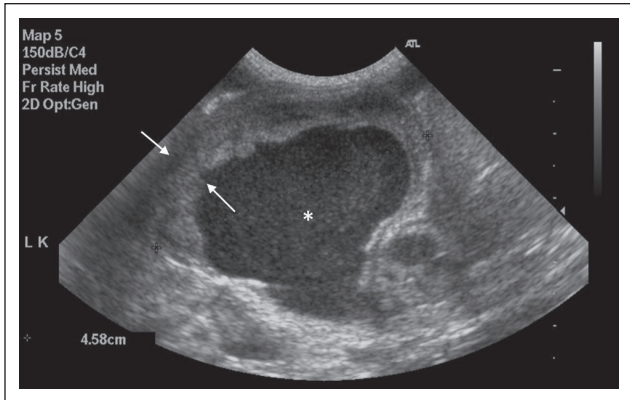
Hydronephrosis in the left kidney at abdominal ultrasound. Rim of renal parenchyma (arrows) and echogenic intrapelvic fluid (*)
